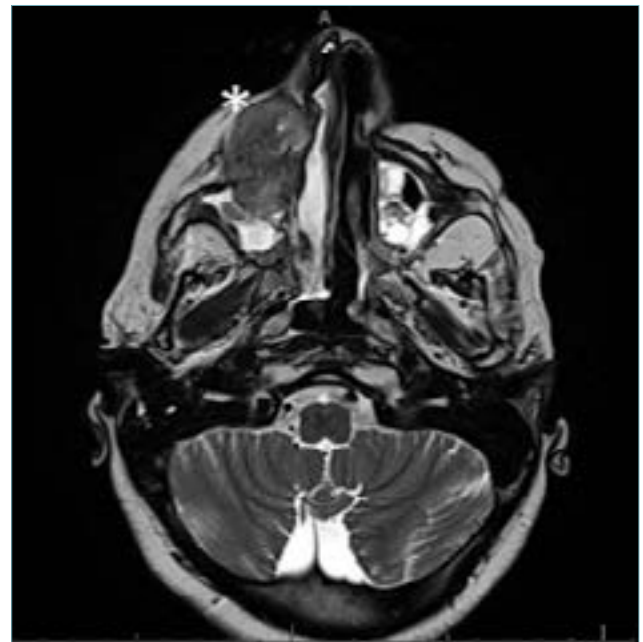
MRI of the mass of the right nasal cavity.
